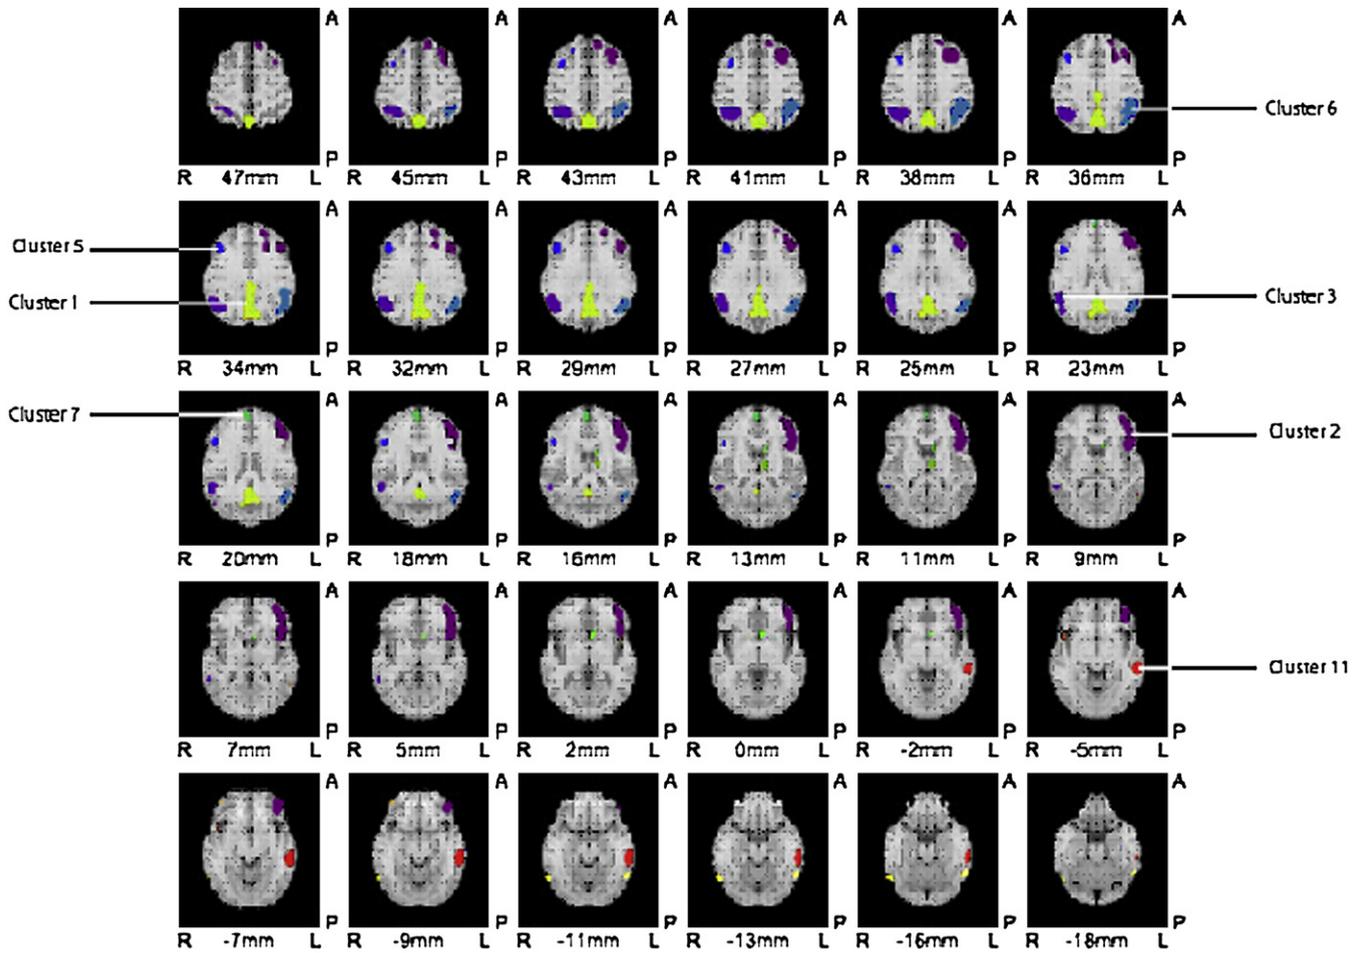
Cluster division for SVM based on the subtraction of ¹⁸FDG-PET scans of healthy controls from all MCI patients after age regression (ie, MCI template). Note the similarity to AD pattern. Top of image is anterior; image left is patient's right side. Each cluster has been colored to aid in identification.
